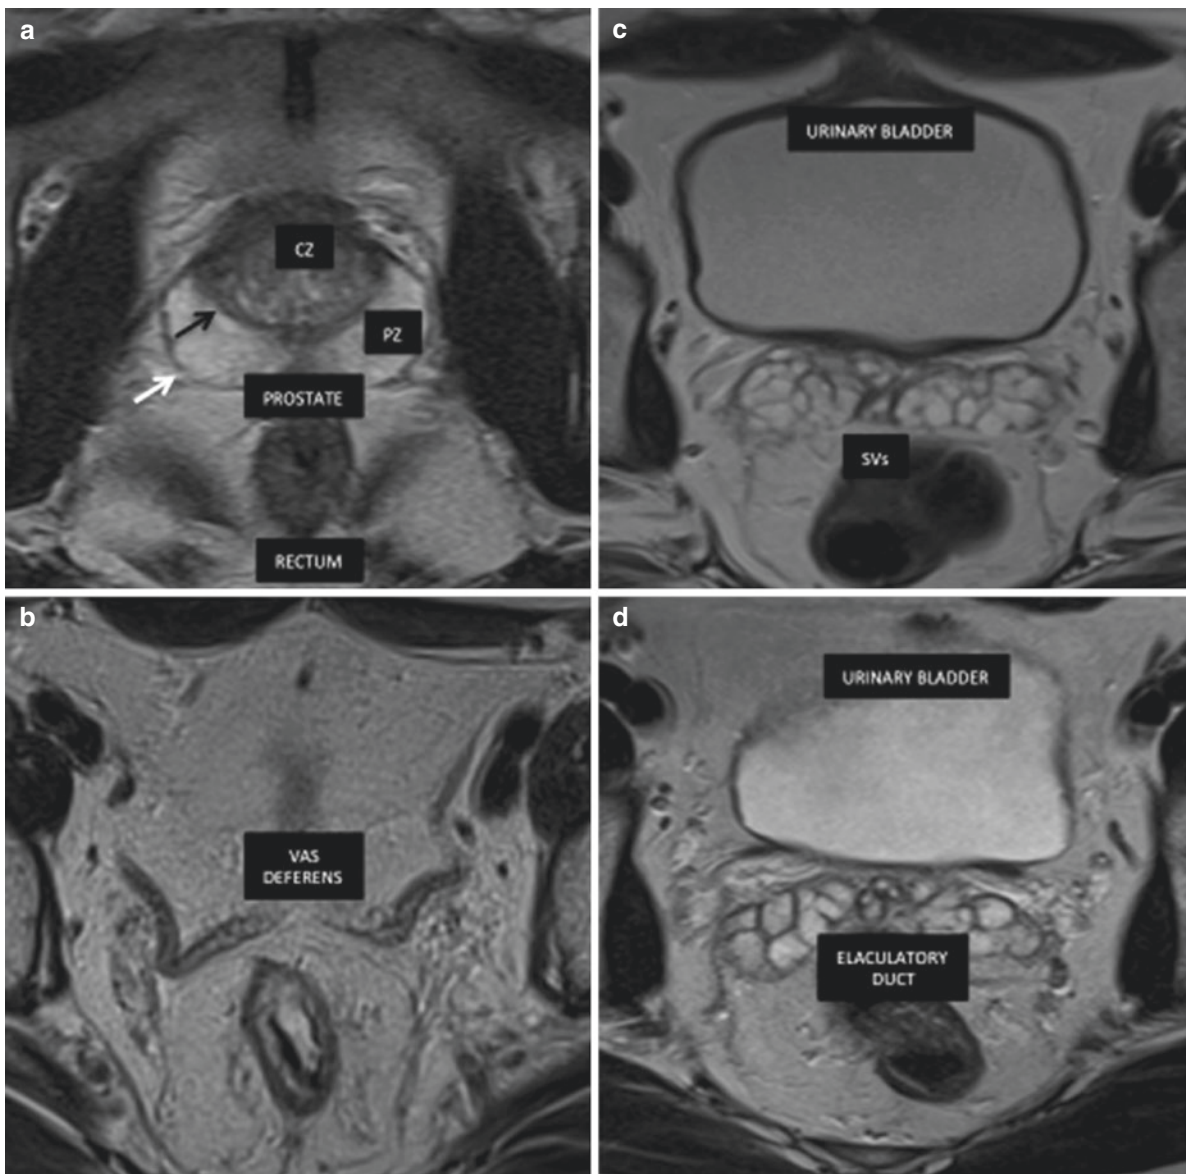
Anatomy of the prostate, seminal vesicles and vas deferens. MRI modality of choice due to its soft tissue contrast and multi-planar capabilities and no ionizing radiation. (a) Axial T2-weighted MR image shows peripheral zone (PZ) of the prostate with homogeneous hyperintensity, and the central zone (CZ) with hypointensity of the prostate capsule
